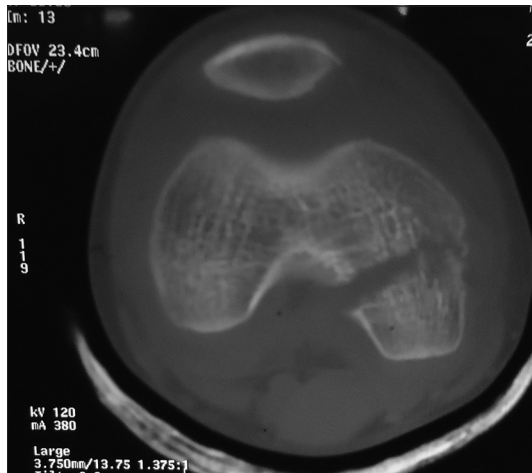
Axial CT with Hoffa's fracture
